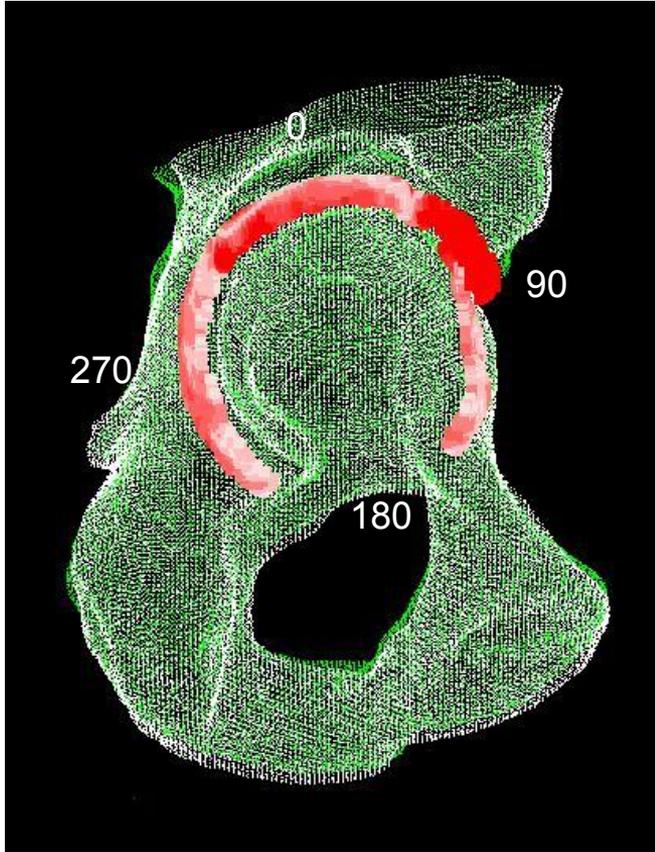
Symptomatic (green) and Asymptomatic (white) CT reconstructions of the same patient from figure 1 mapped on to each other. Areas of protrusion of the symptomatic hip are marked in red.
